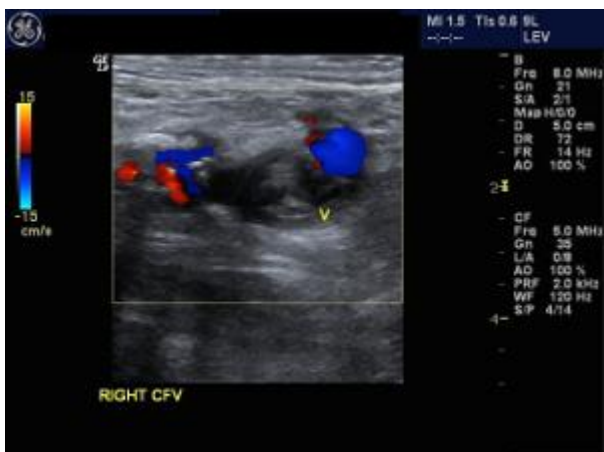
Color Doppler image of the right common femoral vein
